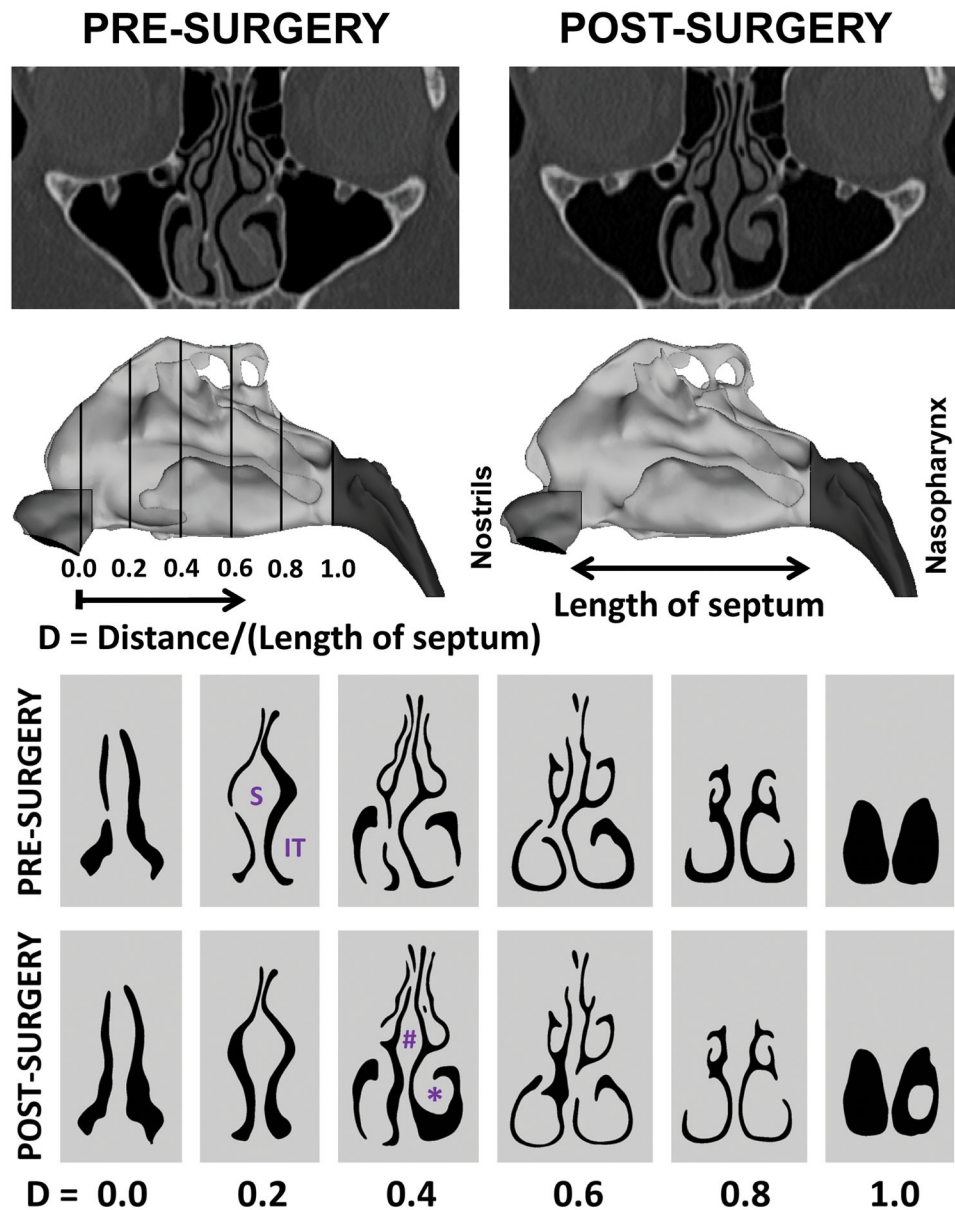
(Top) Pre- and post-surgery CT scans and computational models of the nasal anatomy of a patient with nasal obstruction. Dark gray: nasopharynx. Light gray: nasal cavity. Middle-tone gray: nasal vestibule. (Bottom) Cross-sections by distance from nostrils. Abbreviations: S = septum; IT = inferior turbinate; # = septoplasty; * = turbinate reduction.
